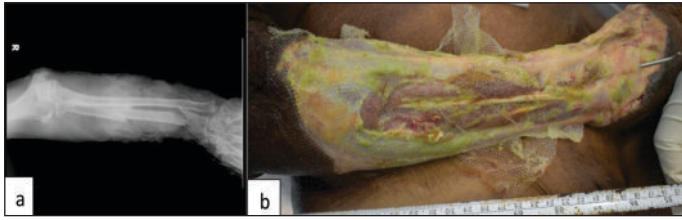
(a) X-ray of right elbow, forearm and wrist showing radius segmental shaft fracture; 1(b) Partially healed wound of right forearm, wrist and hand with K wire insitu.
